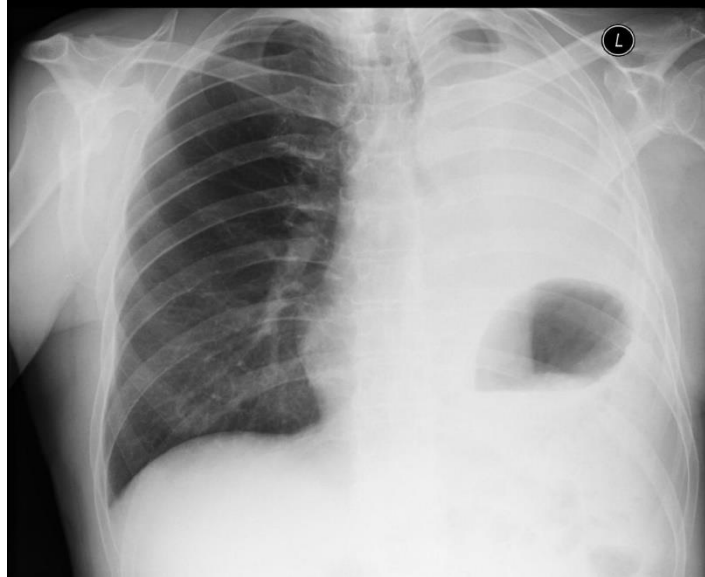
X-ray image of lungs after a left pneumonectomy [20].
